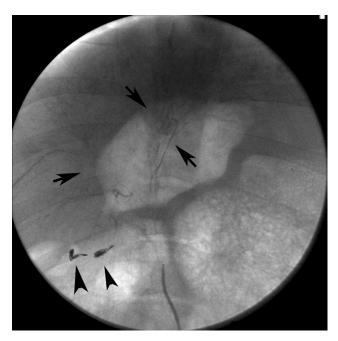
Transcatheter arterial hepatic embolization using ethanol/iodized oil mixture. Close-up of an anteroposterior radiograph of the abdomen in a later phase of the procedure shows embolic mixture in portal vein branches (arrows). Metallic coils are noted in the gastroduodenal artery (arrowheads). The coils are used to prevent nontarget embolization.
